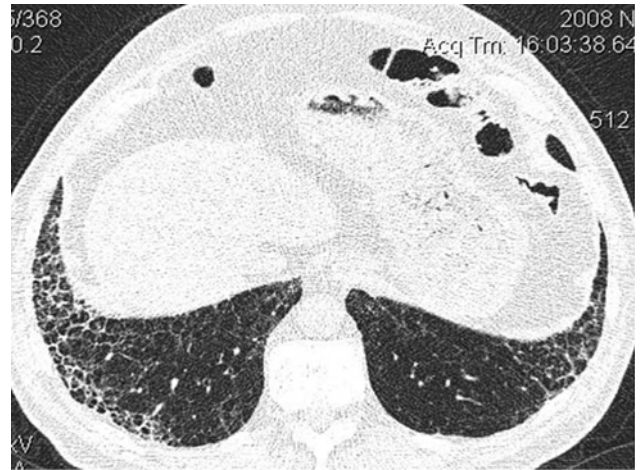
A 59-year-old man with low-dose thin-section CT abnormalities resembling a UIP-like pattern. Transverse thin-section CT image shows reticular with traction bronchiectasis with minimal honeycombing, predominantly distributed in the subpleural-basal regions.
